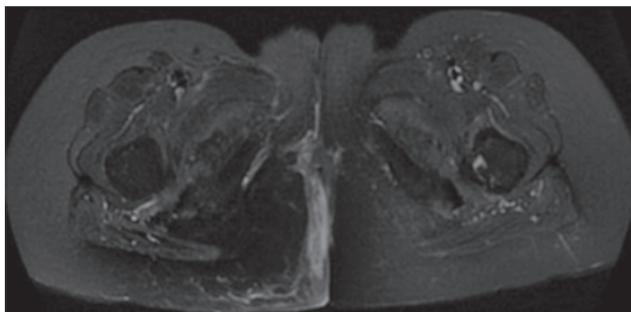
Pelvic magnetic resonance imaging showed a cellulitis in the right perianal region
